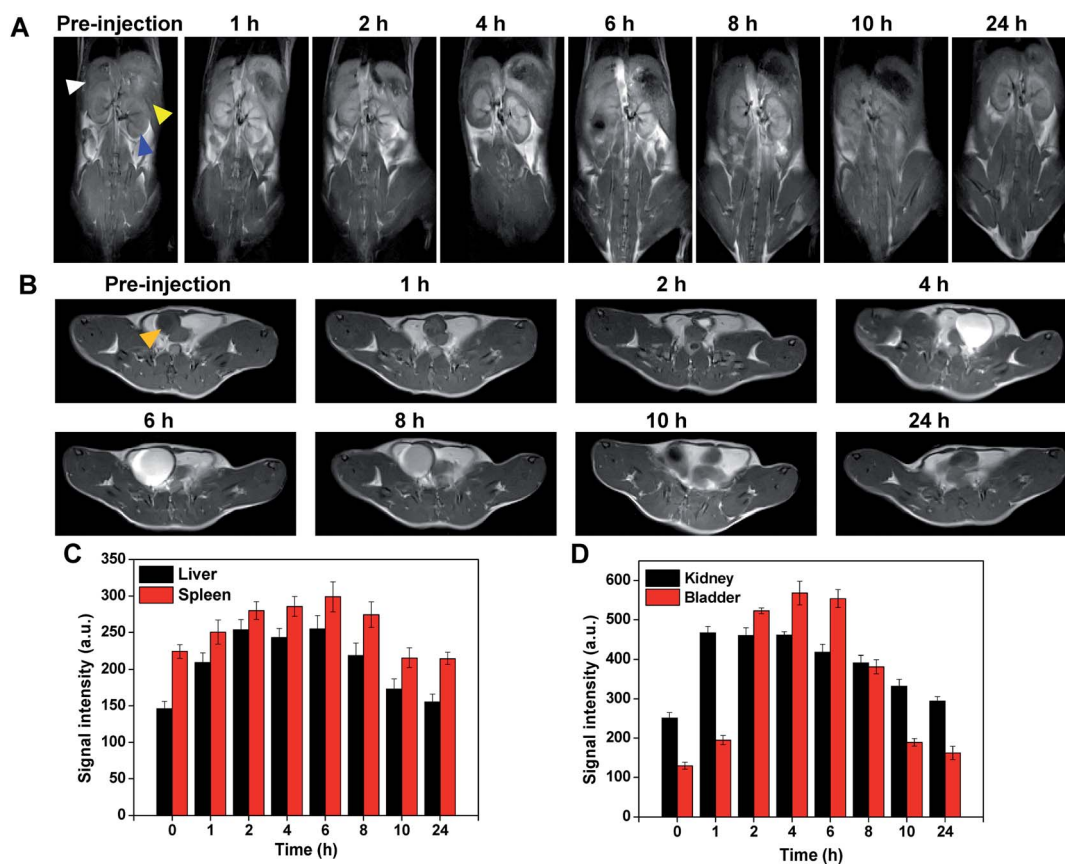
In vivo* MR imaging of different metabolic organs. (A and B) T1-weighted MRI images of Au-Gd NCs in the liver (white arrowhead), spleen (yellow arrowhead), kidney (blue arrowhead), and bladder (orange arrowhead). (C and D) Quantitative analysis of liver, spleen, kidney, and bladder signal intensity at different time points.
